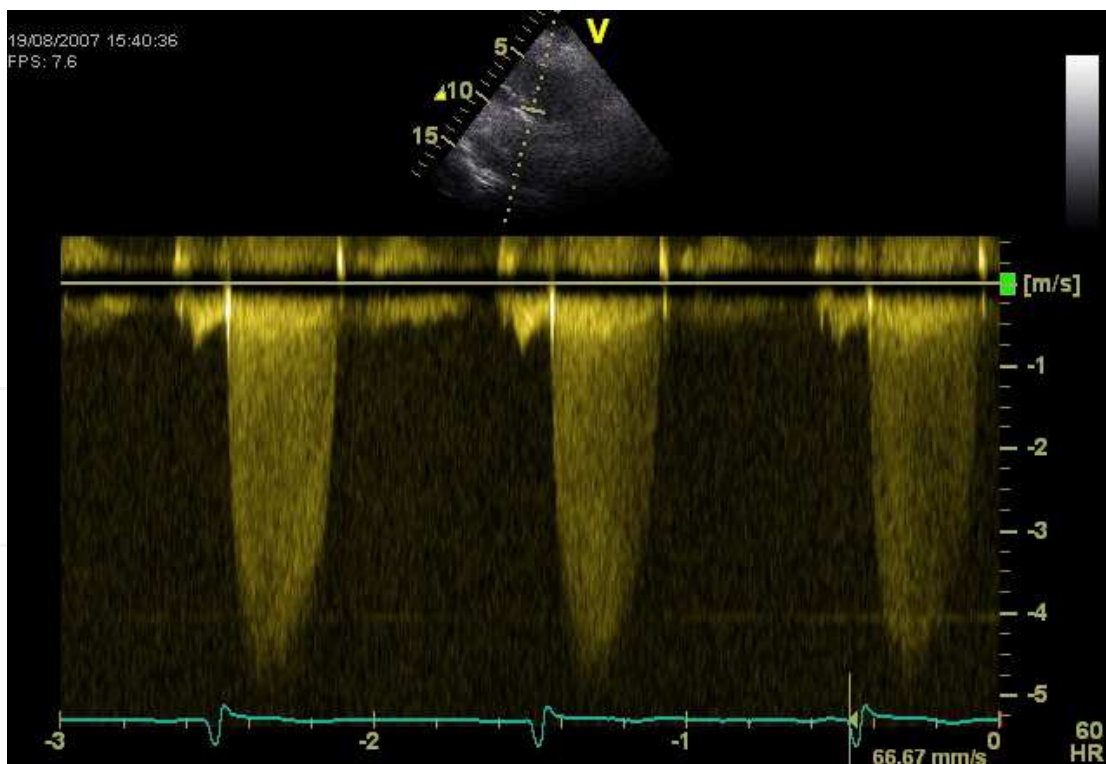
Continues Doppler velocity of the aortic valve, in a patient with high pressure gradient and normal EF, before aortic valve replacement.
